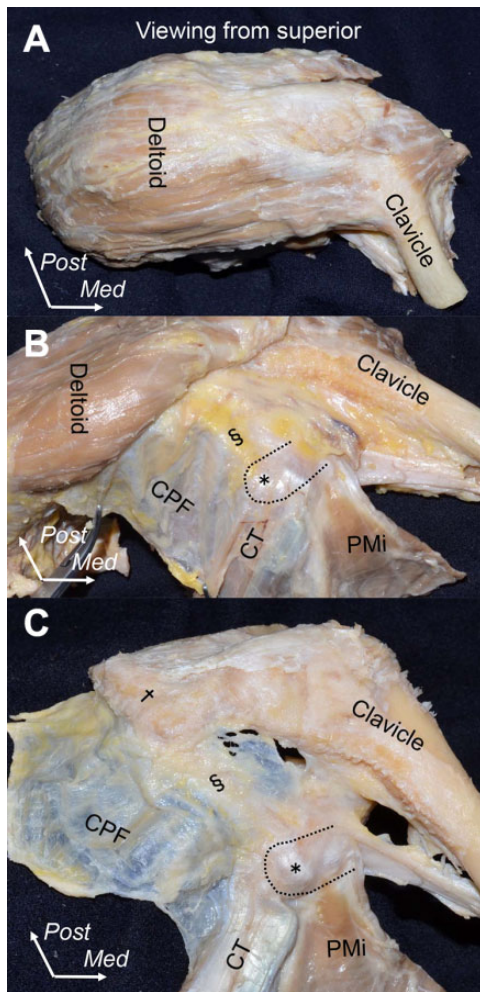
Dissection of the clavicopectoral fascia and coracoacromial ligament from the superior aspect. (A) Superior aspect of the deltoid muscle and clavicle after removal of skin and subcutaneous tissues. (B) The coracoacromial ligament (S) and clavicopectoral fascia were observed after detachment of the deltoid muscle from the clavicle and lateral reflection. (C) The coracoacromial ligament (S) appears as a thick part of the clavicopectoral fascia after removal of the deltoid muscle from the acromion (t) and the synovial tissue above the coracoacromial ligament. The black dotted area and asterisk in (B) and (C) mark the coracoid process. CPF, clavicopectoral fascia; CT, conjoint tendon; Med, medial; PMi, pectoralis minor; Post, posterior.
